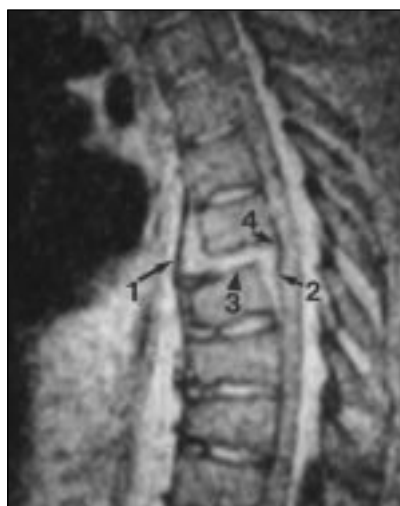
Ligament stripping in 450-lb (202.5-kg) 35-year-old man ejected from motor vehicle. Lateral radiographs (not shown) were nondiagnostic. Sagittal gradient-echo MR image (TR/TE, 510/35; flip angle, 20°) obtained on 0.3-T MR scanner shows anterior longitudinal ligament stripped completely away from anterior surface of midthoracic spine vertebral body (1). Similarly, posterior longitudinal ligament is stripped away from posterior vertebral body surface at level of fracture-subluxation (2). Adjacent intervertebral disk is disrupted (3) and thoracic spinal cord is compressed (4).
